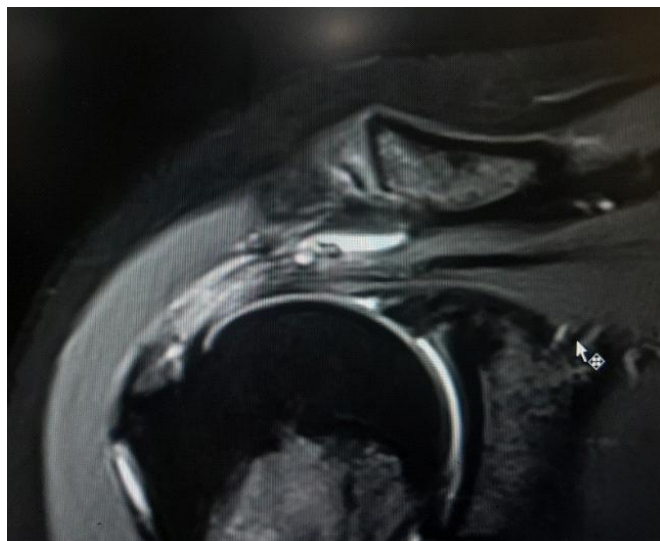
Coronal MRI Shoulder image shows increased signal intensity in Supraspinatus tendon predominately involving Bursal surface with associated subdeltoid subacromial bursitis.
